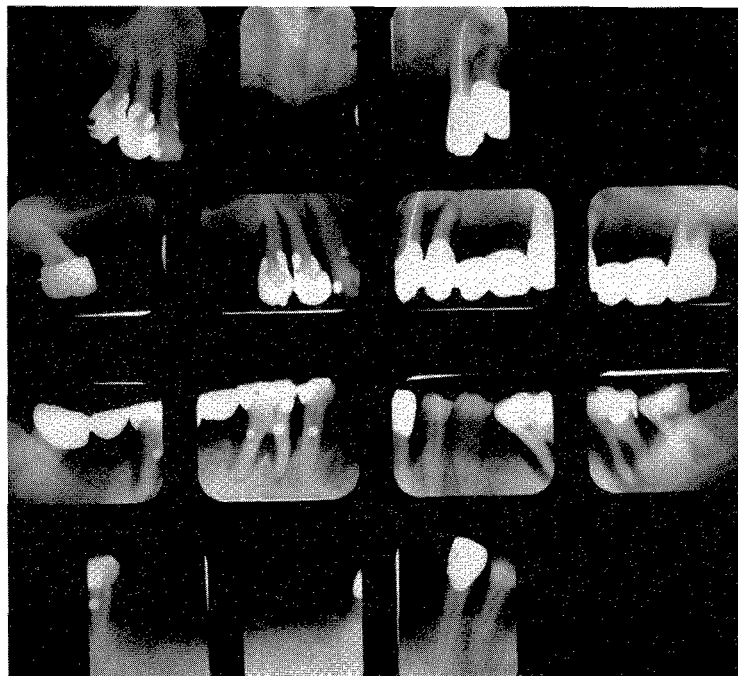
Roentgenograms taken in 1956. Shortly after these were taken, all the upper and lower teeth which were hopelessly involved were removed.
